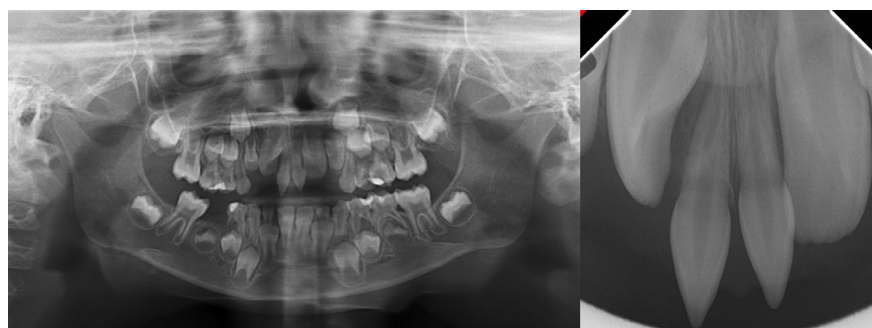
Panoramic radiograph showing 2 erupted mesiodense
